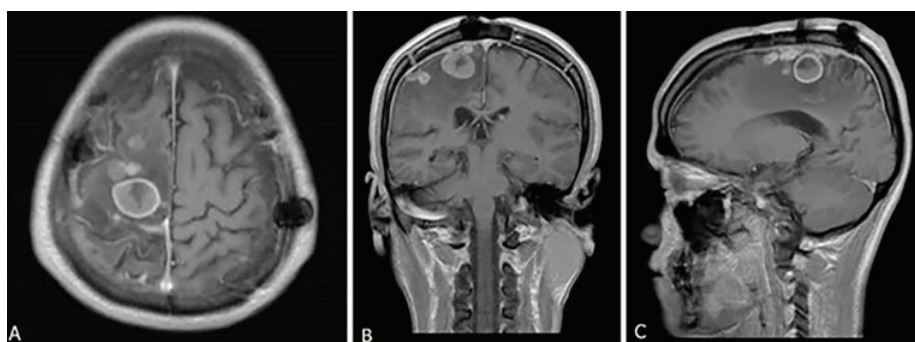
T1-weighted image with gadolinium contrast on MRI before the surgery. (A) Axial Section; (B) Coronal Section; (C) Sagittal Section.
